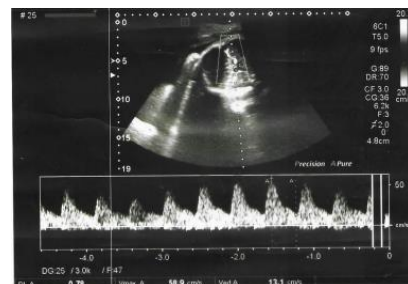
Middle cerebral artery Doppler showing increased end diastolic flow (Reducing cerebral blood flow resistance)
